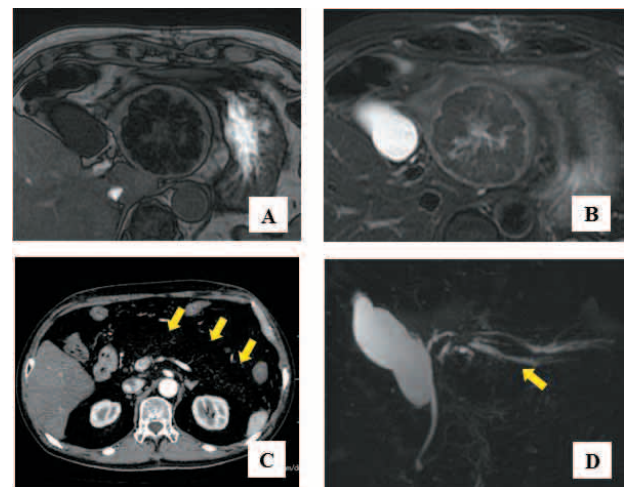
Magnetic resonance imaging (MRI) showed the tumor with internal low intensity on T1-weighted image (A), and iso intensity on T2-weighted image (B). On CT image, pancreas is almost invisible due to lipomatosis (C, arrows). Magnetic resonance cholangiopancreatography showed dilation of the peripheral left intrahepatic bile duct (D, arrow).
